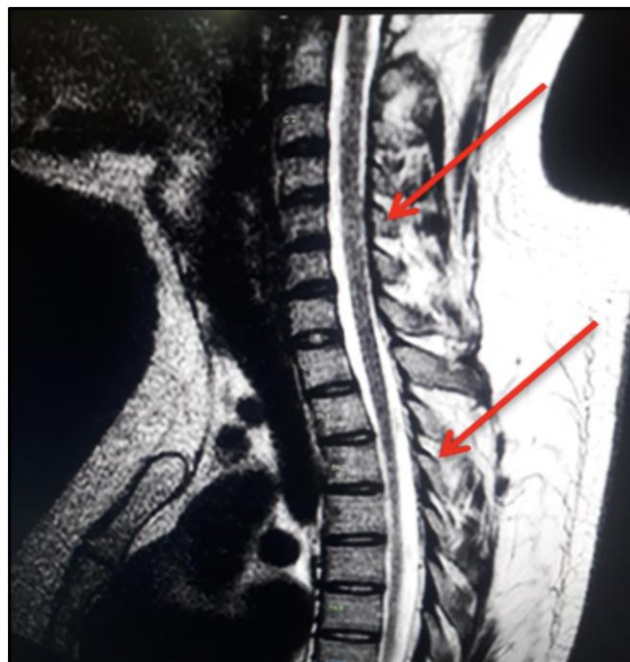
Spinal MRI result of NMOSD patient of a 22-year-old male with longitudinal extensive transversal myelitis involving C3-6 and Th2-6
